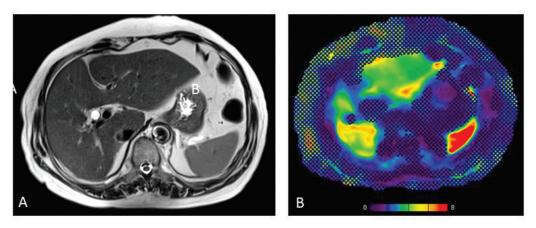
Autoimmune hepatitis in a 63-year-old woman.* (A) T2-weighted axial image shows liver enlargement with rounding of liver margin. (B) Confidence stiffness map shows liver stiffness measurement of 4.1 kPa suggesting advanced fibrosis. Biopsy showed moderate interface hepatitis with periportal fibrosis. Serum immunoglobulin G level and serum antinuclear antibody level were elevated.
